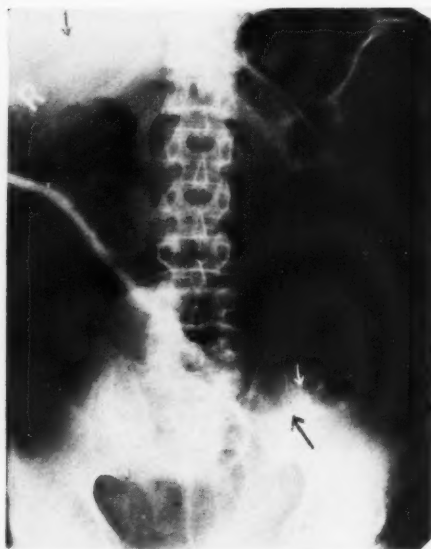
Roentgenogram of abdomen, supine position, in a case of volvulus of sigmoid flexure with acute obstruction. The enormously distended sigmoid colon (arrows) is shown extending to the right and upward. The remainder of the colon is also distended but to a much lesser degree. Note the point of obstruction in the descending colon (white arrow) which must be proximal to the gas-filled sigmoid.
